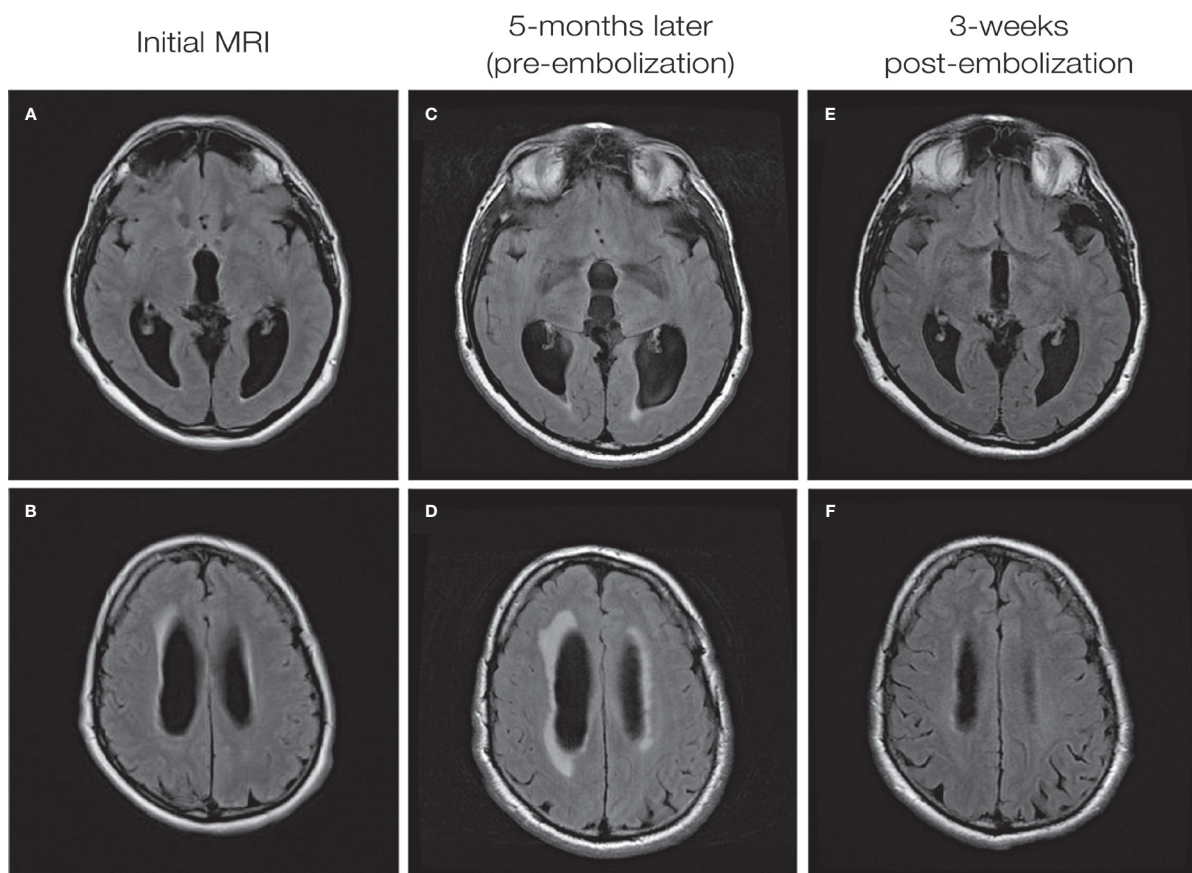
Axial FLAIR MRI performed at the time of presentation to medical attention (A and B), at the time of symptom progression (C and D), and 3-weeks (E and F) post-embolization. Note the progression of ventricular size and transependymal edema prior to treatment, and near resolution of hydrocephalus 3-weeks after partial targeted embolization of the choroidal-type AVM.
